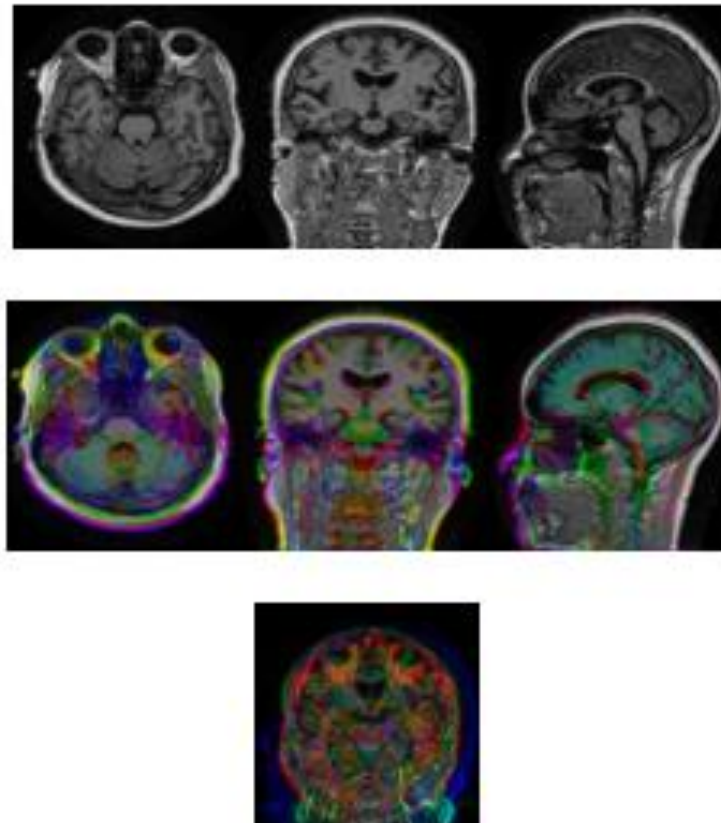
Images created from MRI data
